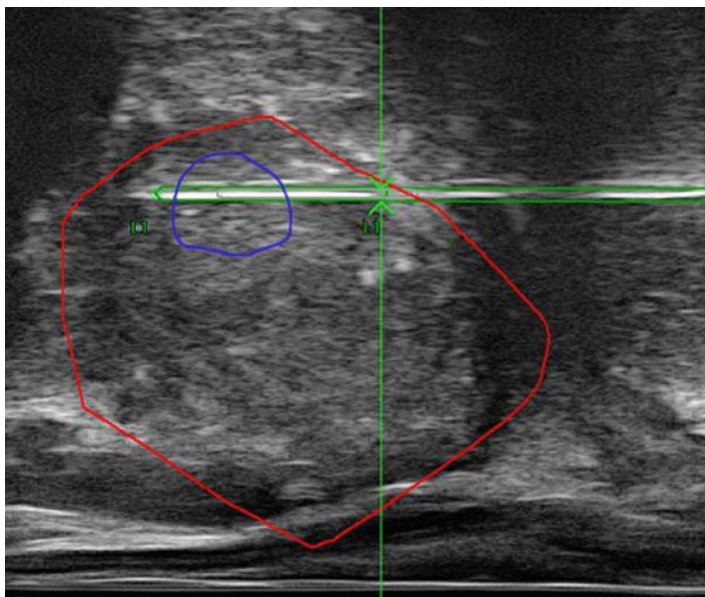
Image guided prostate biopsy. MR segmented prostate (*red*) and tumor suspect region (*blue*) fused with live transrectal ultrasound. Biopsy needle inserted according to planned biopsy corridor (*green/gray*)
